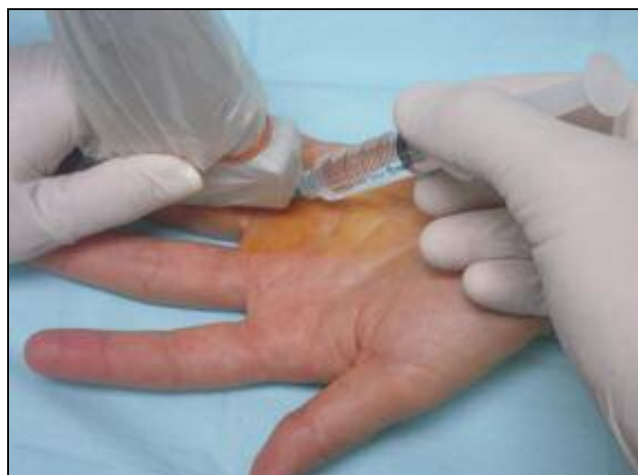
Lidocaine injection technique with dry needling using ultrasound guidance to optimize visualization of cord tissue.
